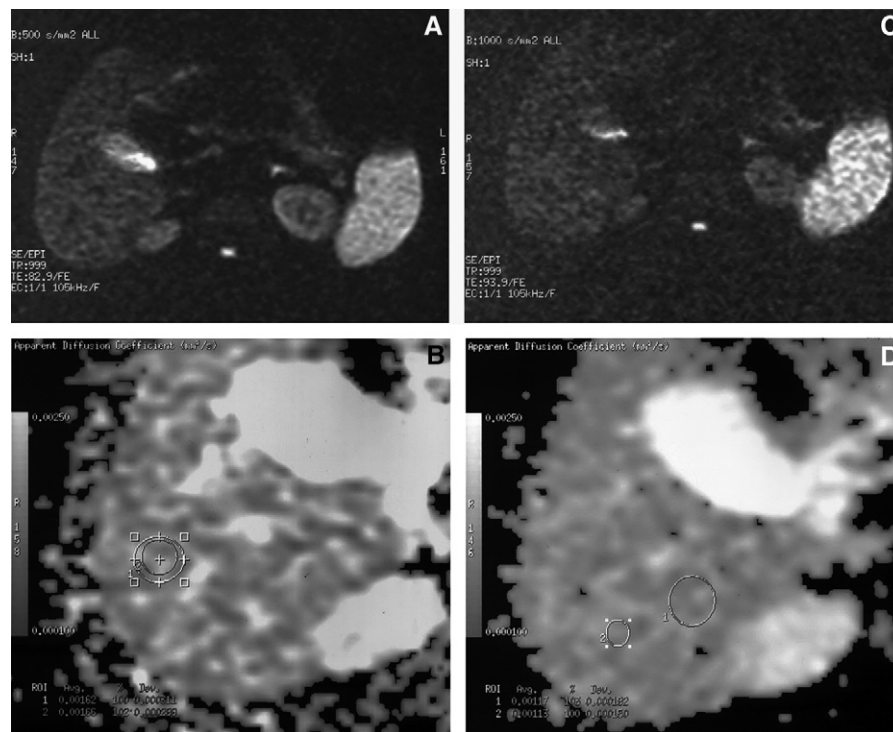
Axial echo-planar diffusion-weighted images (DWIs) of the liver at b values of 500 and 1000 s/mm², and their corresponding apparent diffusion coefficients (ADC) maps in a 53-year-old man with chronic hepatitis B (stage I on biopsy): (A) DWI at b = 500; (B) the corresponding ADC map (ADC value with small regions of interest [ROI], 1.66 mm²/s; ACD value with large ROI, 1.62 mm²/s); (C) DWI at b = 1000; and (D) the corresponding ADC map (ADC value with small ROI, 1.13 mm²/s; ACD value with a large ROI, 1.17 mm²/s).
